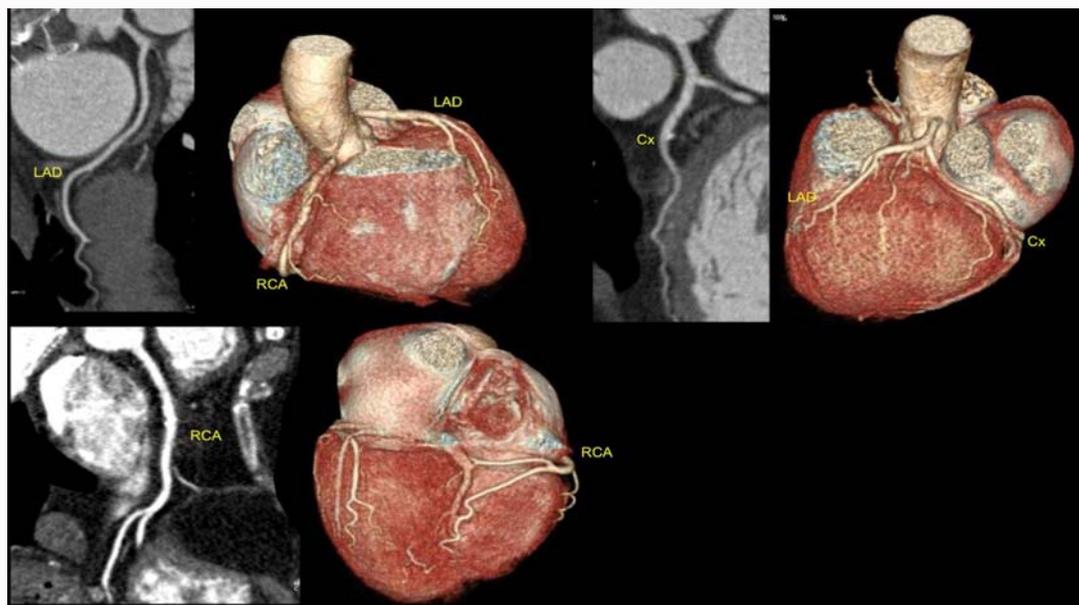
Coronary computed tomography angiography with coronary calcium score of 29.8U. Left anterior descending artery at its mid portion shows a mild obstruction (CAD-RADS2), and the right coronary artery exhibits two mild obstructive lesions (CAD-RADS2). LAD: Left Anterior Descending Artery; RCA: Right Coronary Artery; Cx: Circumflex Artery
